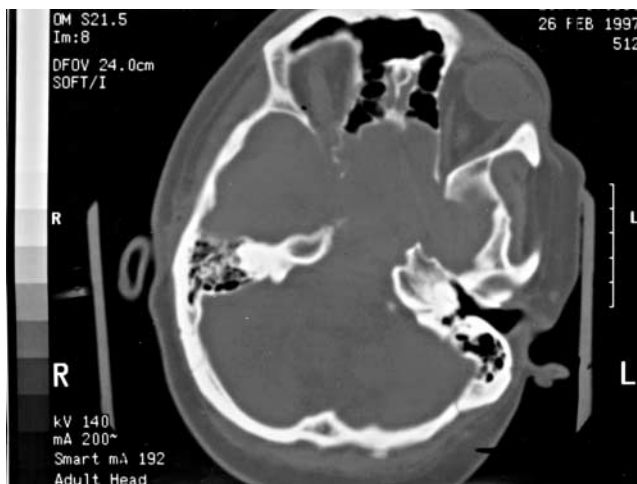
CT transverse view showing destruction of the sphenoid sinus
